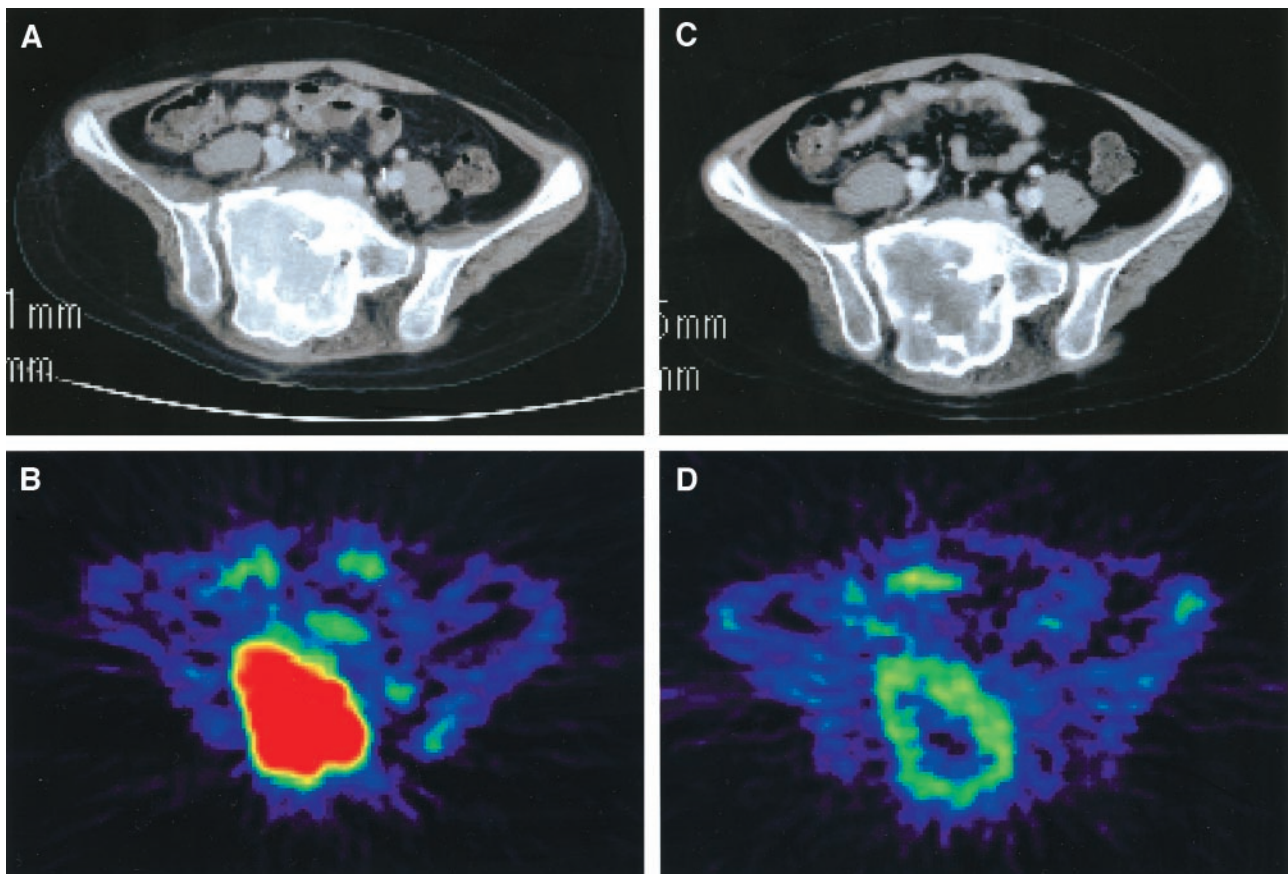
A 13-year-old male who received 70.4 GyE to the whole pelvis for sacral osteosarcoma. A, computed tomography (CT) image showed a large mass in the sacrum. B, baseline whether L-[methyl- ^{11}C]-methionine uptake demonstrated a high homogeneous mass in the region as shown in CT image. C, CT image still revealed a large mass after CIRT. D, after CIRT, a moderately large region of absent whether L-[methyl- ^{11}C]-methionine uptake was seen within the tumor, indicative of necrosis.
